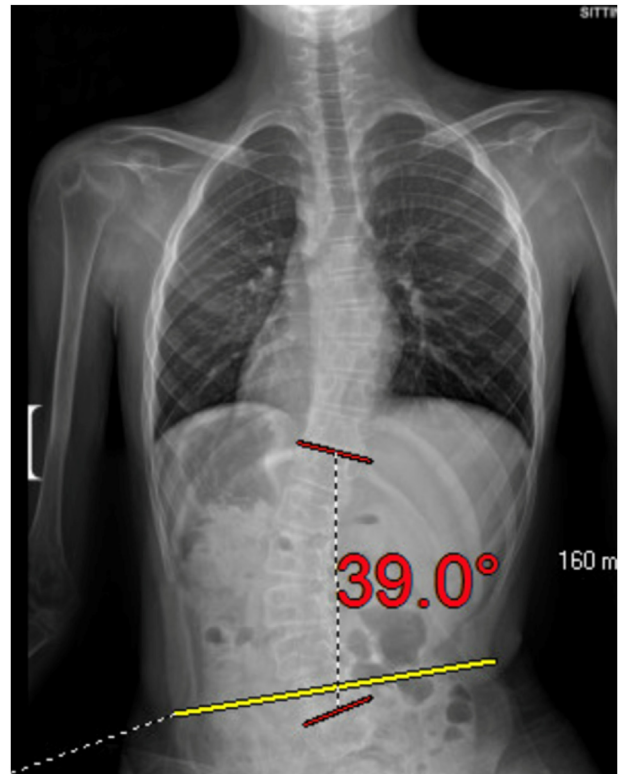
Preoperative anteroposterior radiograph of a 13-year-old male with Duchenne muscular dystrophy with 39° of scoliosis and 10° of pelvic obliquity.
